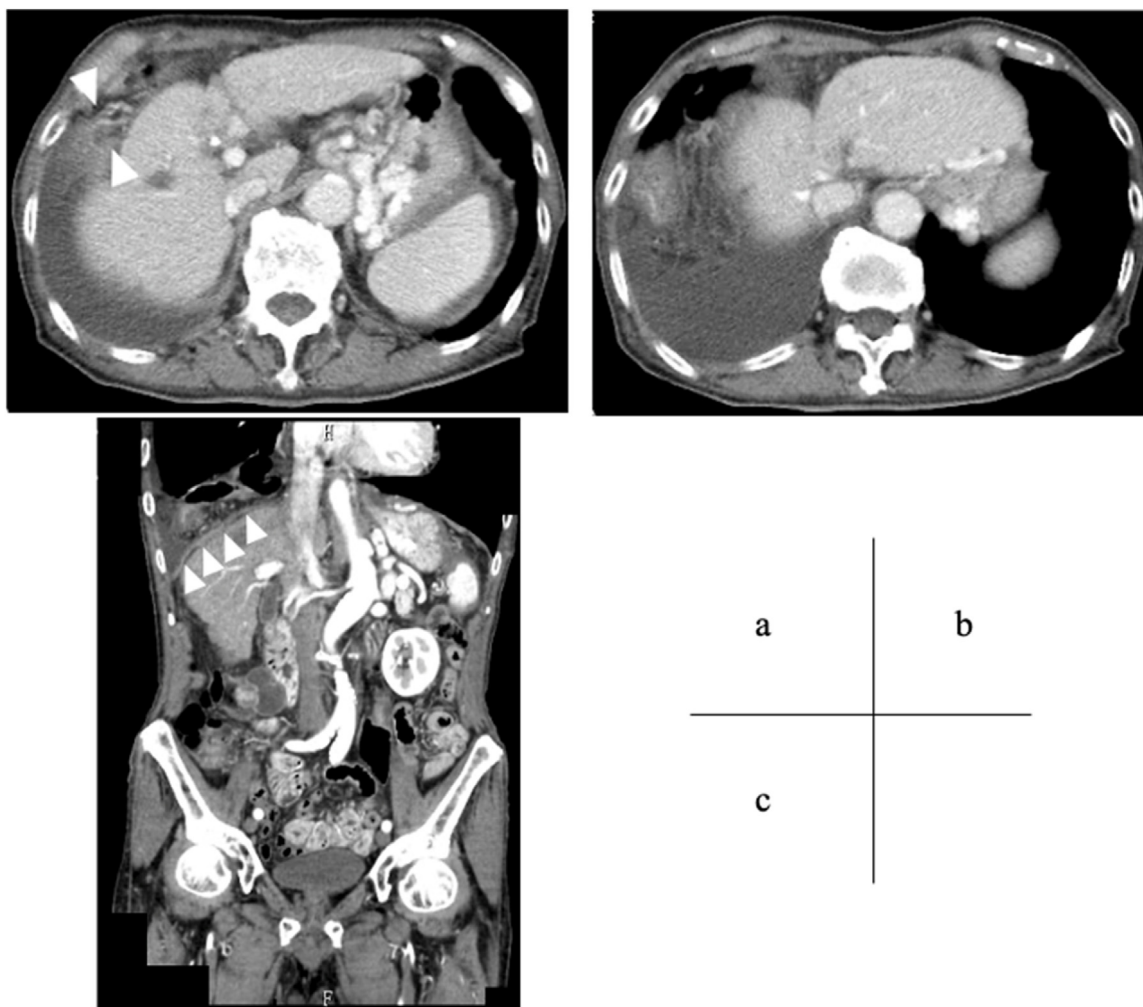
Contrast-enhanced computed tomography (CT) upon admission. The transverse colon is within the right thoracic cavity. (a) Transverse CT image showing the diaphragmatic hernia. The defect in the diaphragm is between the two arrowheads. (b) Transverse CT image showing the transverse colon in the right thoracic cavity, with pleural effusion. (c) Coronal abdominal CT image showing the diaphragmatic hernia. The arrowheads are at the diaphragm.
